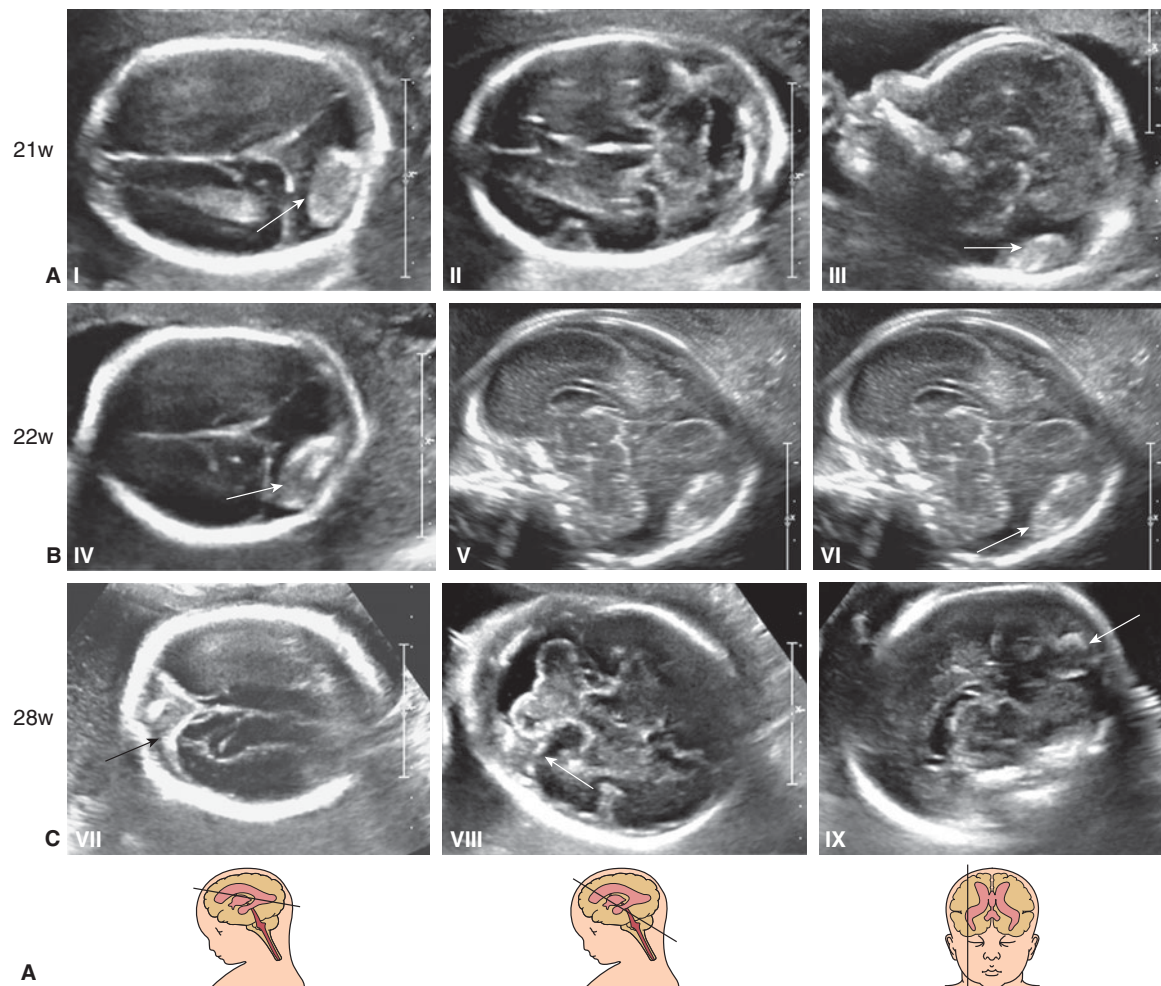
(A) Thrombosis of the lateral sinus in a patient detected at 21 postmenstrual weeks during an otherwise uneventful pregnancy. The posterior hyperechoic, oval mass is just above the cerebellum and appears to be supratentorial, with absence of signals on color Doppler imaging. There was no ventriculomegaly, and the brain appeared otherwise normal. The mass was surrounded by a sonolucent area. Clinically, there were no signs of fetal anemia. Chromosomal abnormalities, infections, and thrombophilic disorders were ruled out. (Courtesy of Maria Del Rio, Barcelona, MD, Spain.) Axial (A) (I, II) and parasagittal (III) sections at 21 postmenstrual weeks demonstrating the hyperechoic clot (arrows). (B) (IV–VI) Images obtained through the same planes at 22 weeks showing almost no changes. (C) (VII–IX) Follow-up images at 28 postmenstrual weeks using the previous planes for comparison. One can hardly see the lesion (arrows), and it looks as if the clot is decreasing in size. The rest of the anatomy appears to be normal.
